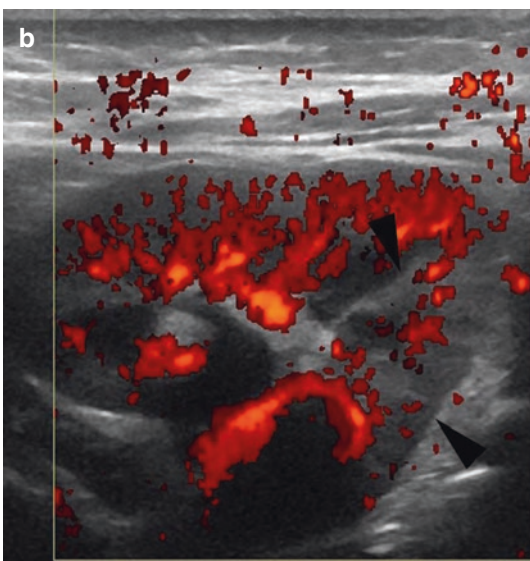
Nephritis. Axial sonogram (a) demonstrates pelvic wall thickening, increased peripelvic fat thickening, and a focal nephritis: area of increased echogenicity
